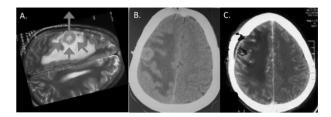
Shows the technique through which small craniotomy works. 'A' is the preoperative MRI of the patient showing a small metastasis with significant perilesional edema. If proper positioning is made with the tumor at the highest position, the edematous forces (red arrows) will aid in forcing it out. Since the site of the craniotomy is near to the tumor, no brain tissue/veins get compressed between the edges of the tumor and dura. 'B' shows the marker CT depicting a radio-opaque marker at the site of the mass. 'C' shows the postoperative scan with a small craniotomy. Note the surrounding cortex expands and takes space of the tumor.
